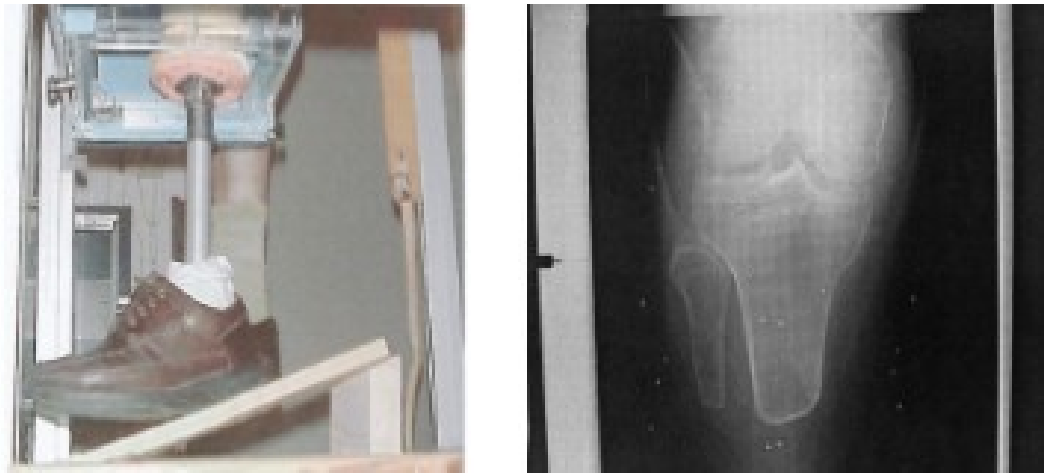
Radiographic method of pistoning measurement (Söderberg *et al.*, 2003).
